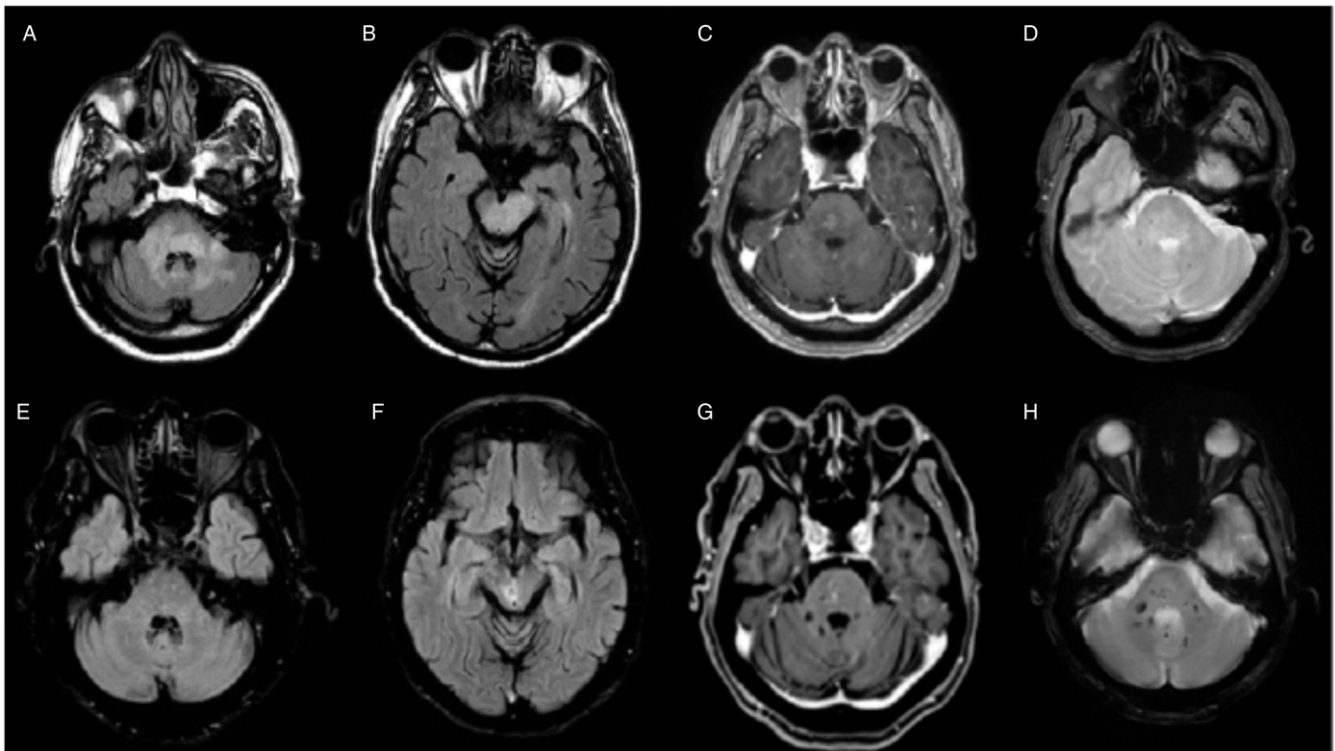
(A–D) Extensive involvement of the brainstem by T2 hyperintense (A, B) and ring-enhancing lesions post-gadolinium (C), with some microbleeds (D). E–H: Marked improvement of the lesion burden both on T2 FLAIR (E, F) as well as of the ring-enhancing lesions (G), though with the persistence of brainstem and cerebellar microbleeds as shown by T2* hypointensities (H). Please note some inherent differences in contrast windowing and slice thickness and orientation due to images acquired in scanners of different vendors under different conditions.
